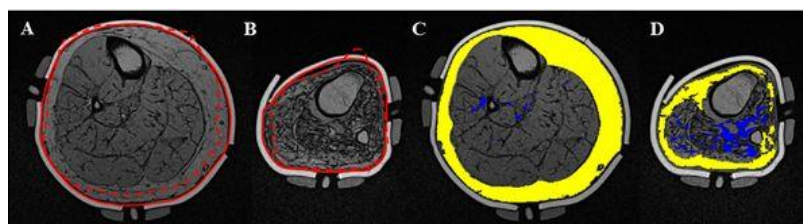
Corresponding transverse section MR images displaying one participant's intact (A & C) and residual limb (B & D) baseline. Note: red represents the limb outline at baseline (solid) and 60 mmHg cuff pressure (dashed), yellow represents superficial adipose mask and blue represents muscle infiltrating adipose mask
